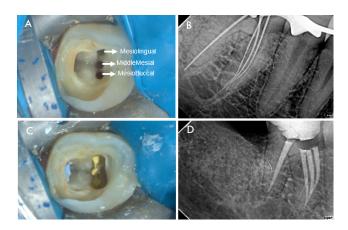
A: Clinical Image of mesial root with three canals; B: Working Length; C: Post Obturation Clinical Photograph; D: Post-Operative Radiograph.
